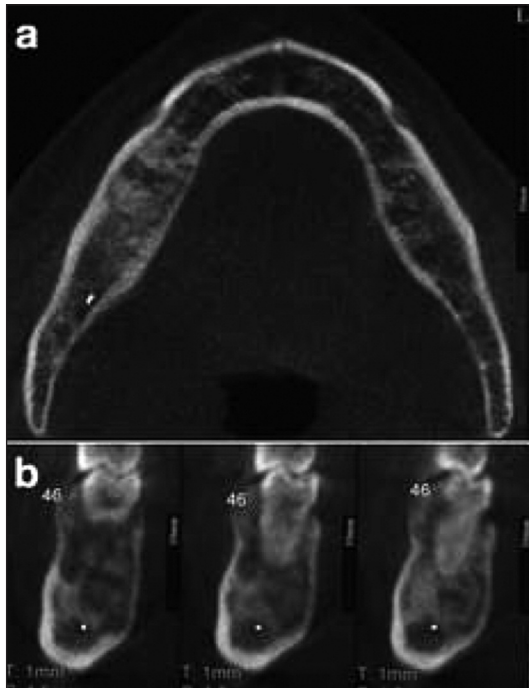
Computed tomography views a) axial view showing the mixed lesion in the right mandible, b) Cross-sectional views show the lesion causing thinning of buccal and lingual cortical bone.
